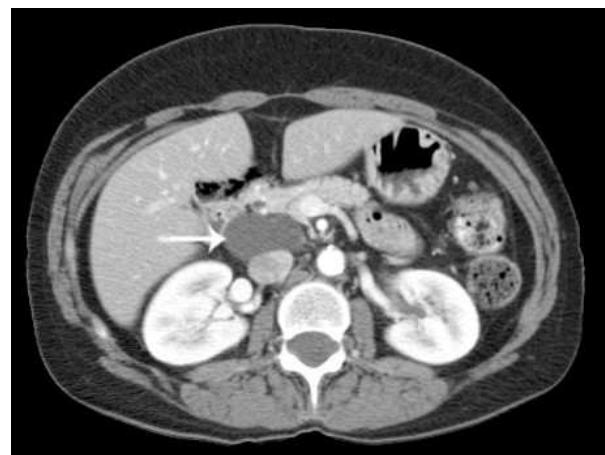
CT scan image showing the cystic lesion (arrow).
